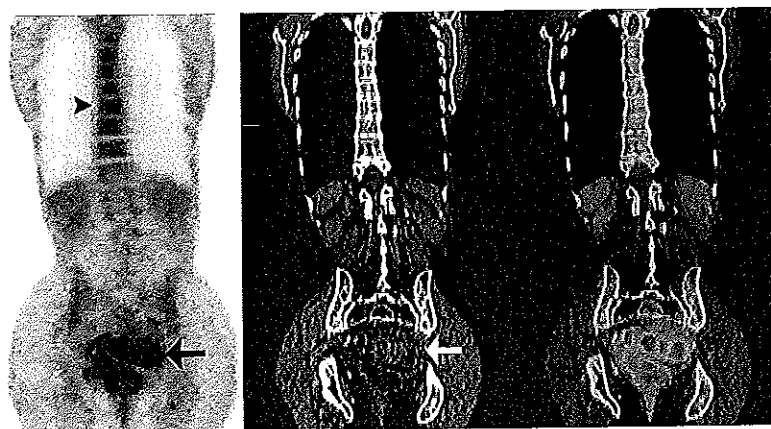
Ulcerative colitis. Coronal PET, CT, and fused PET/CT images in a patient investigated for a solitary pulmonary nodule show segmental uptake within the sigmoid colon with associated mural thickening and pericolic inflammation. Note also the mild and uniform increase in activity throughout the bone marrow. Further clinical evaluation, including flexible sigmoidoscopy, revealed ulcerative colitis, and a normocytic anaemia. The pulmonary nodule was non-FDG avid and felt to be benign.
